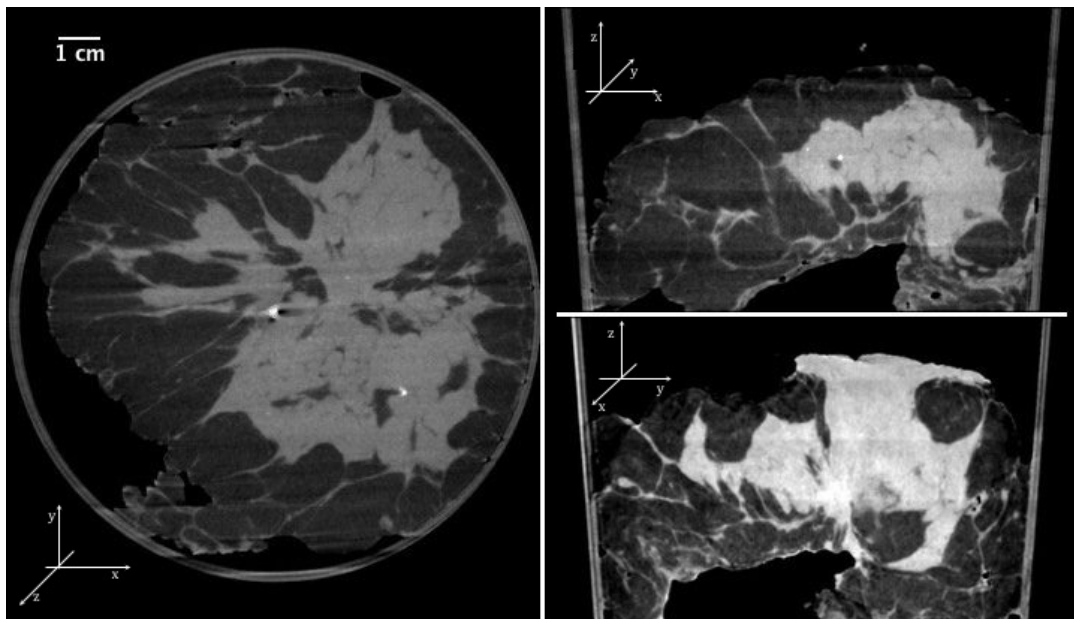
Tomographic reconstruction of Right Breast. On the left the conventional view (plane parallel to the x-ray beam). On the right the two related orthogonal views, above the transverse plane and below the sagittal one. The dataset is the one acquired at 5.71 m and 38 keV , using the classical FBP reconstruction method and pre-processing data with the TIE-Hom phase retrieval algorithm.
